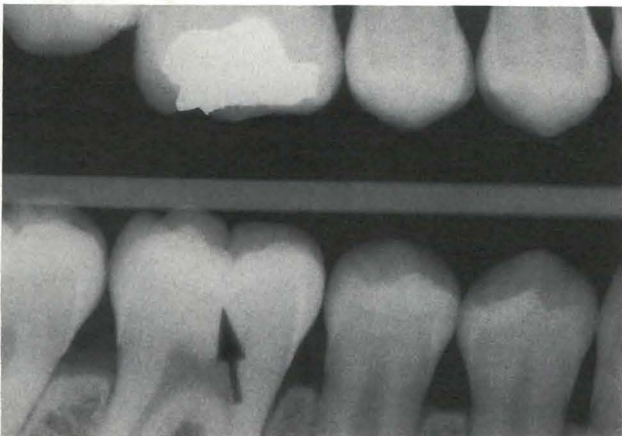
Bitewing radiograph of the tooth in question.
